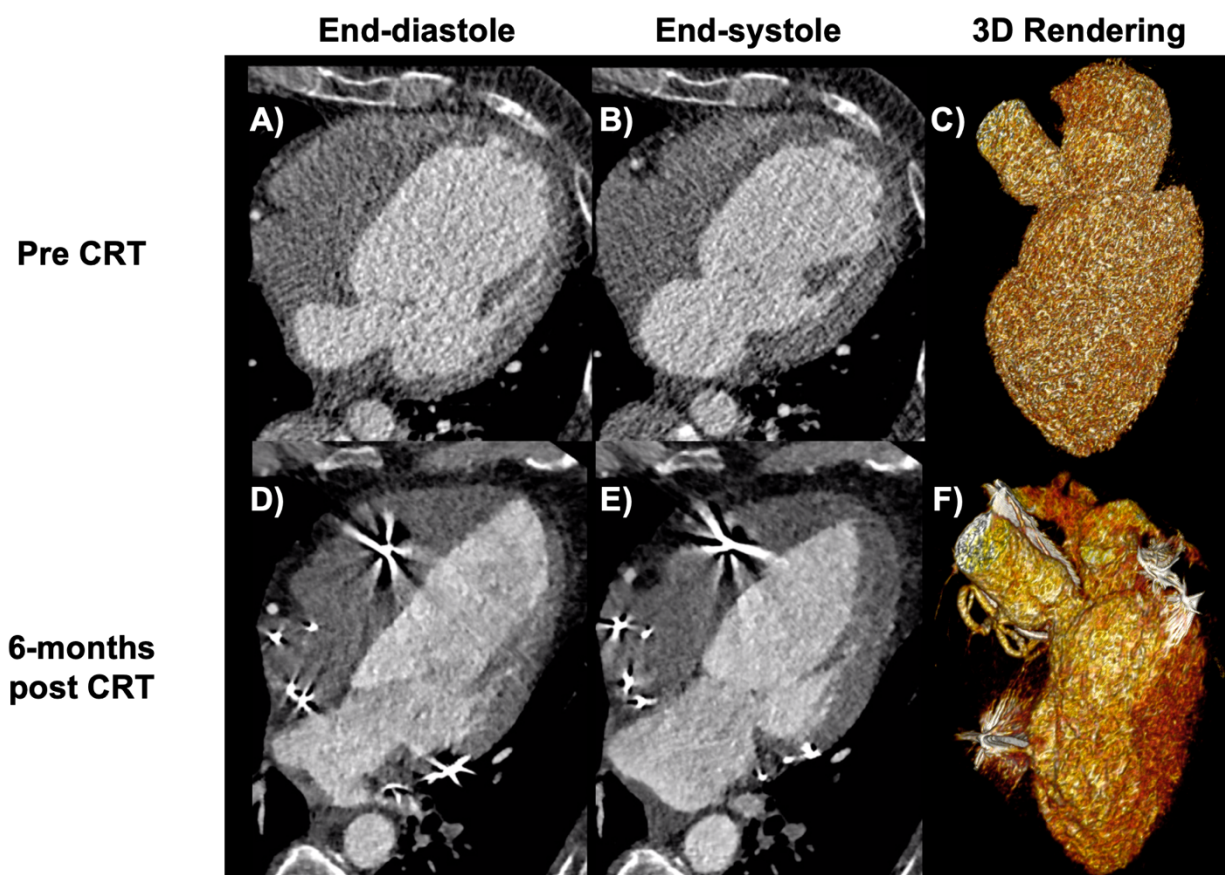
Patients with 4DCT exams pre and post Cardiac Resynchronization Therapy (CRT) were acquired. Axial images pre and post are shown for end-diastole (A,D) and end-systole (B,E). A posterior view of the 3D renderings of the end-diastolic volume pre (C) and post (F) CRT are also shown. The positions of the pacing leads are visualized precisely in both the 2D and 3D CT images.
